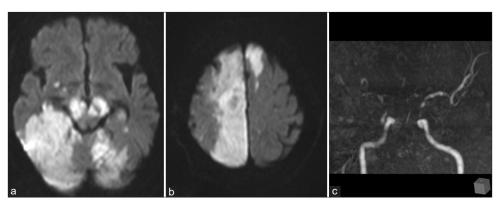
In spite of steroid therapy, (a and b) magnetic resonance imaging showed an exacerbation of the cerebral infarctions and (c) bilateral anterior cerebral arteries, the right internal carotid artery, right middle cerebral artery, and basilar artery were suspected to be occluded.
